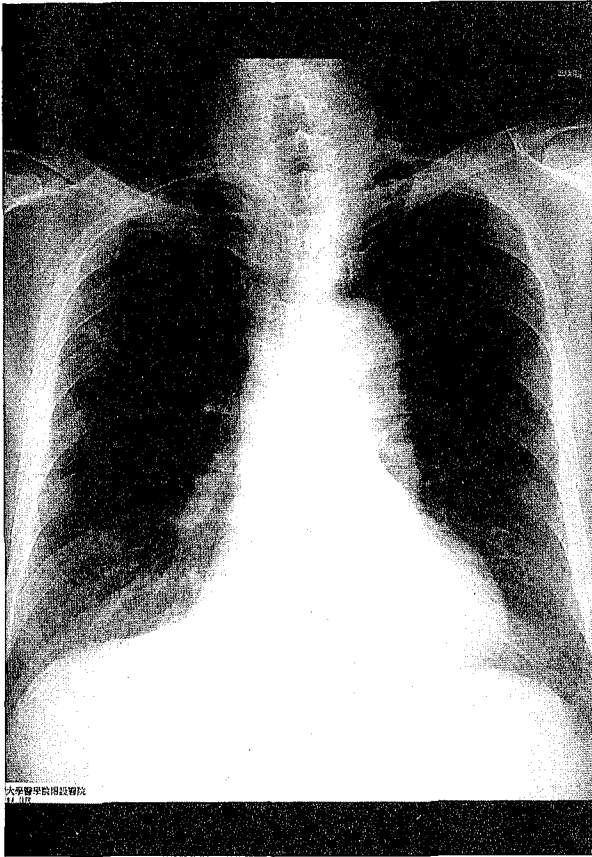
Standing chest radiography at the beginning of this admission showed a well defined pulmonary nodule about 1 cm in diameter at the upper right lobe, as well as reticular-linear infiltrates at the right basal lung, suggesting chronic interstitial disease.
